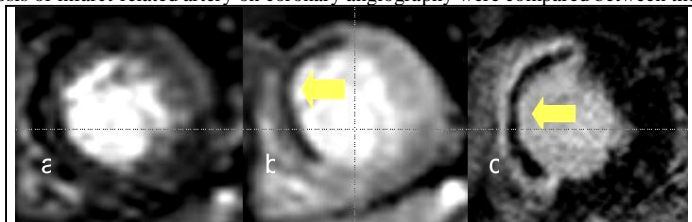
Microvascular obstruction with contrast-enhanced MRI. Hypoenhanced region in early perfusion through delayed enhancement was defined as presence of microvascular obstruction. (a) before enhancement, (b) early perfusion, (c) delayed enhancement
